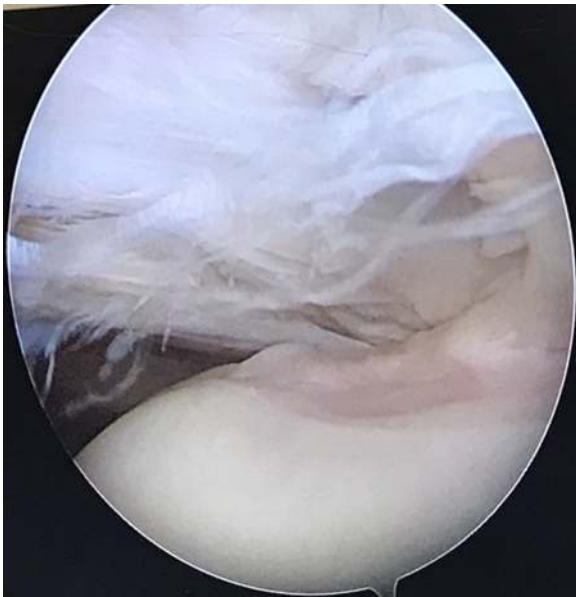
Arthroscopic confirmation of type II lesion in SFA classification [14] corresponding to the tear suspected in the CT arthrography image shown in Fig. 3; the tear was revealed by translating the humeral head posteriorly.
